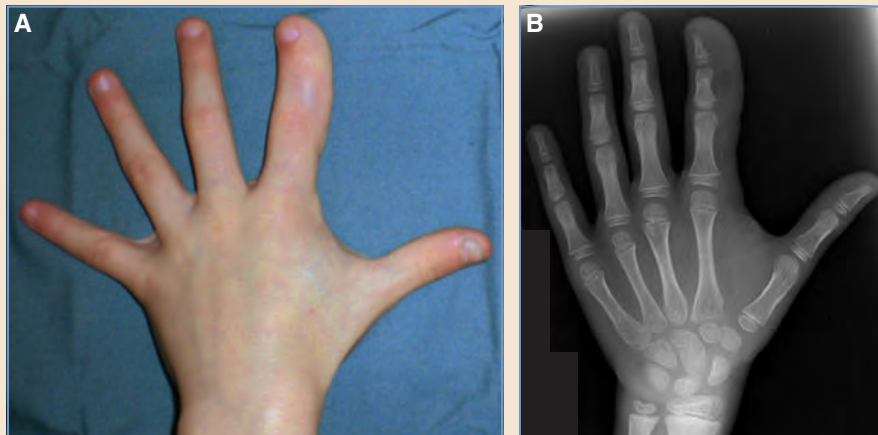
A case involving a single digit. A, Single-digit macrodactyly of the left index finger. B, A PA radiograph of the left hand. Soft tissue volume is increased on the radial side of the digit.
